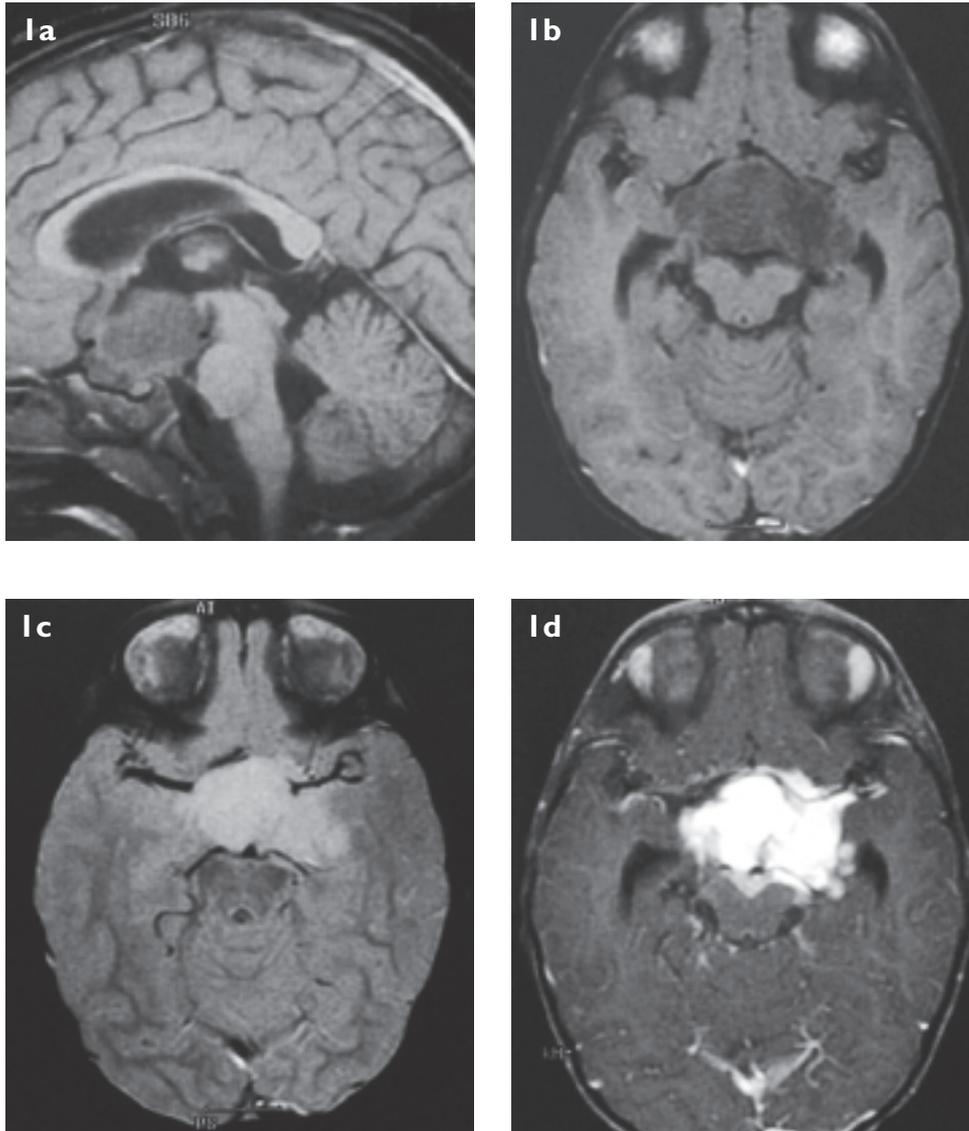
(a) Unenhanced sagittal T1-weighted MR image. (b) Unenhanced axial T1-weighted (c) Unenhanced axial proton density-weighted and (d) enhanced T1-weighted MR images taken at the level of the suprasellar region.
